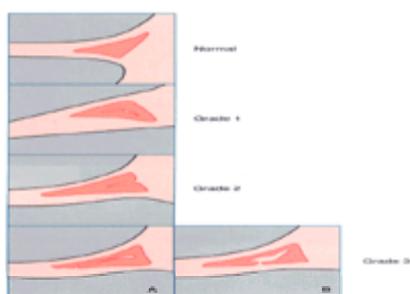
Classification of meniscal change at MRI from normal to tear, according to [Mink et al. \(1993\)](#).
